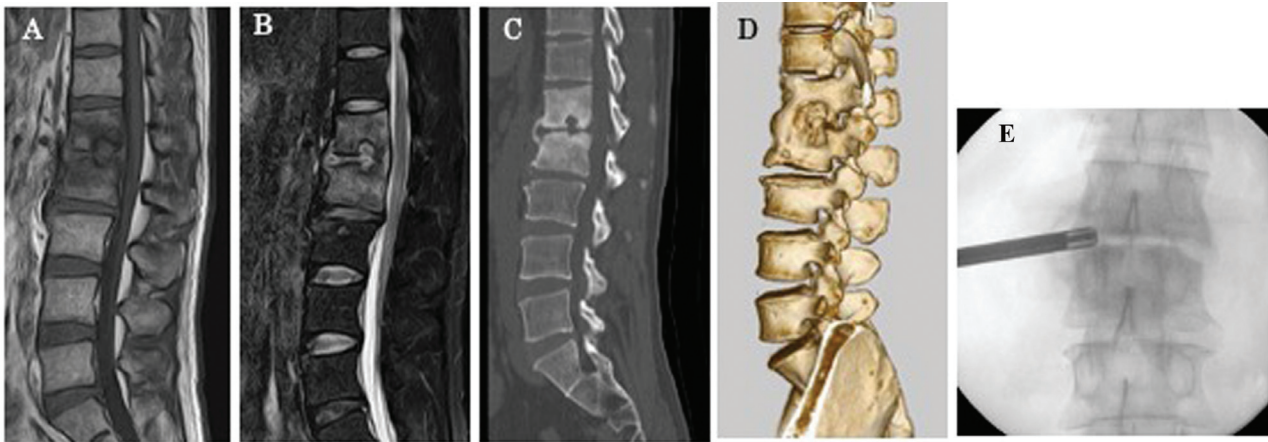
(A) Radiological findings in a case of chronic pyogenic spondylitis diagnosed by full endoscopic discectomy and drainage (FEDD). T1-weighted sagittal magnetic resonance image (MRI) on admission showing hypointense signals in the L2/3 vertebral bodies and the disc space. (B) T2-weighted fat-suppressed sagittal MRI showing hyperintense signals in the L2/3 vertebral bodies and the disc space. Computed tomography (CT), sagittal (C) and three-dimensional CT images, (D) showing bone erosion of the intervertebral endplates and reactive osteosclerosis of L2 and L3. The presence of anterior vertebral fusion is clearly demonstrated, which suggests that this pathology had a chronic course. (E) Suspecting the chronic form of pyogenic spondylitis, FEDD was performed, and the causative organism was identified.
